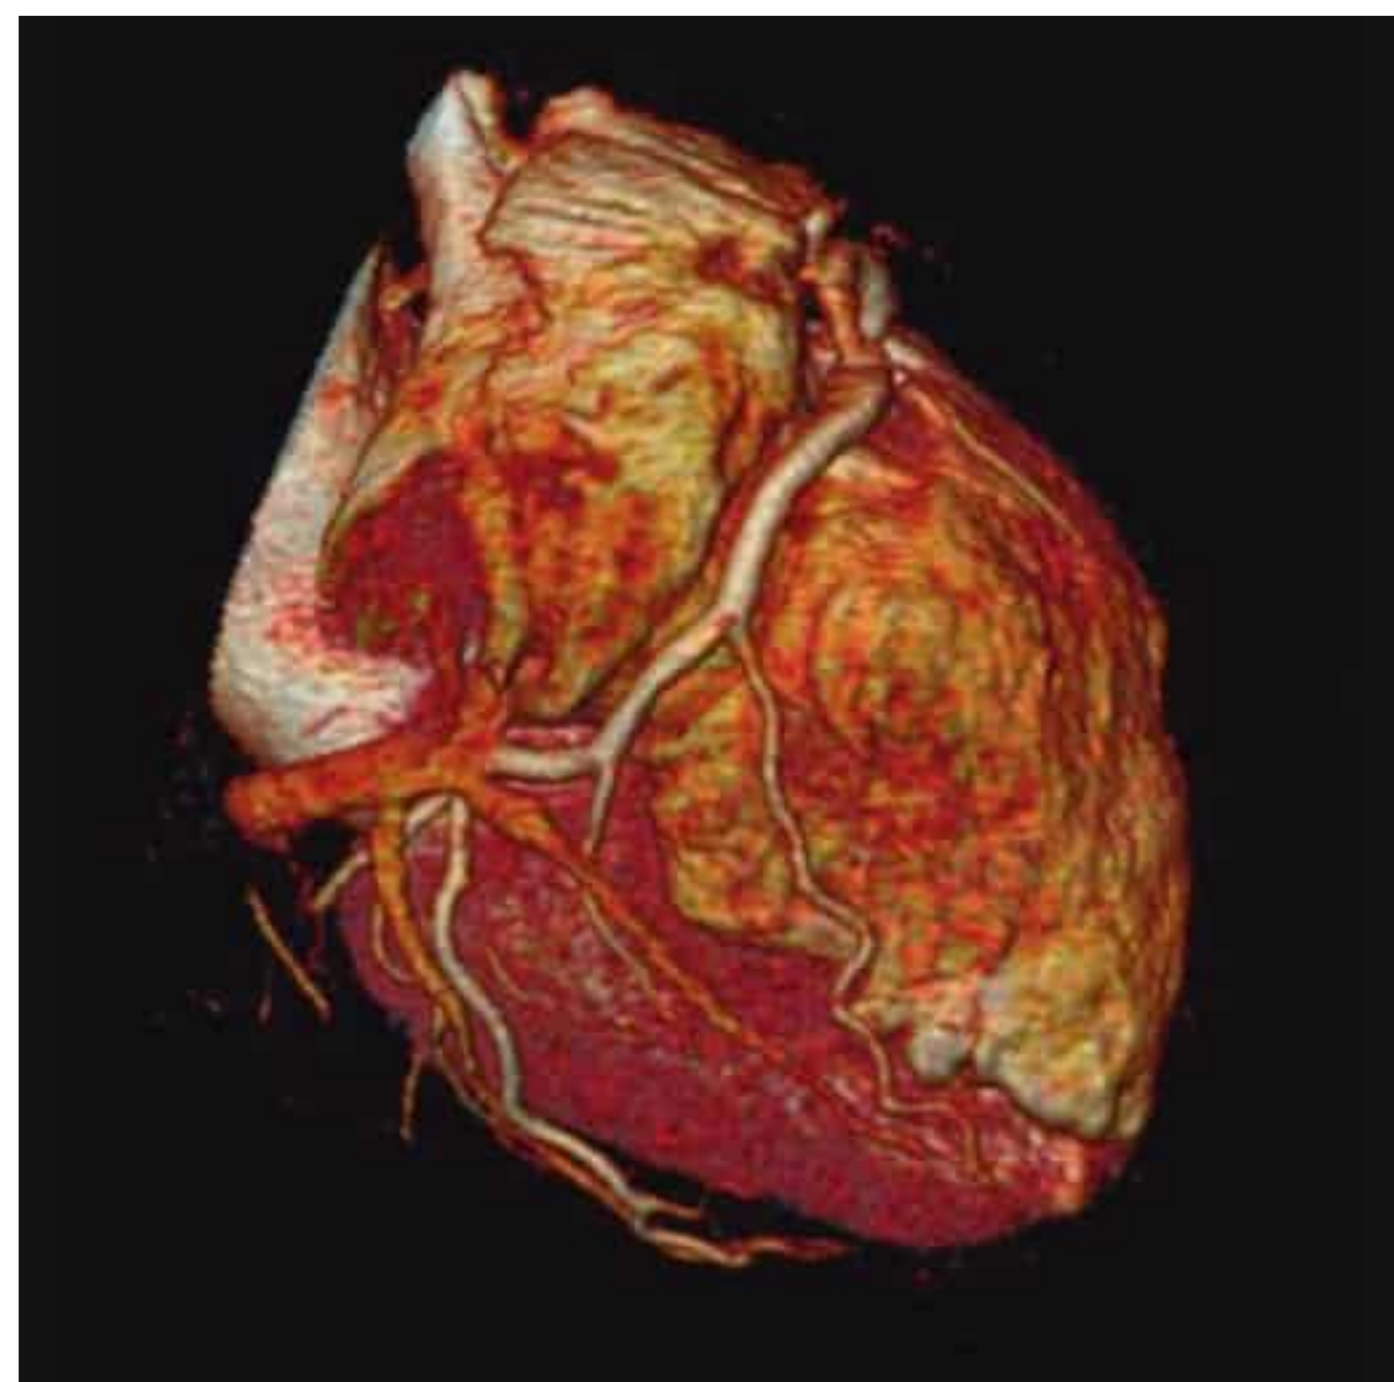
Volume-rendered image from a CT coronary angiography dataset acquired with a 64-slice CT scanner. The image excludes a stenosis of the right coronary artery.
